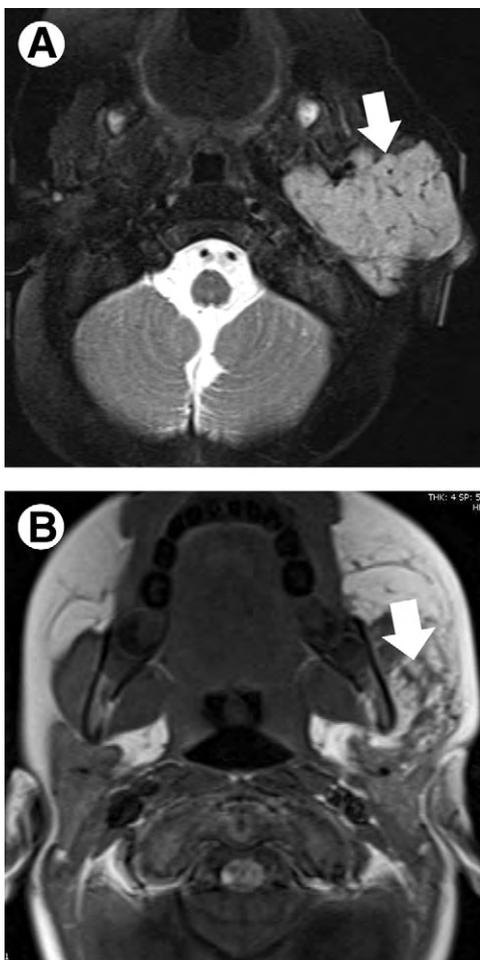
Involuting parotid space infantile hemangioma in a 2-month-old female patient. (A) Axial T2-weighted MR image shows a well defined hyperintense parotid mass with internal flow voids (arrow). (B) Axial T1-weighted MR image 18 months later shows a poorly defined mass partially replaced by adipose tissue consistent with an involuting infantile hemangioma (arrow).
